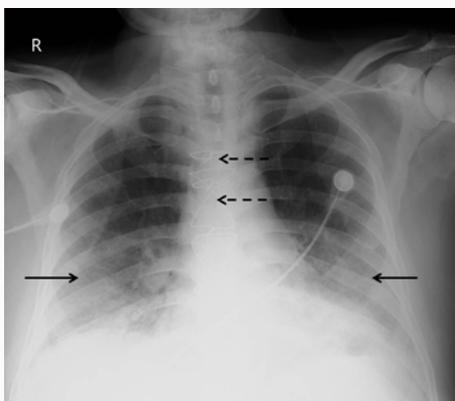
AP chest radiograph of 76-year-old male, known case of coronary artery disease (post CABG), with diffuse air space opacification bilateral mid and lower zones (black arrows). Note the presence of sternal sutures *in situ* (dashed arrow).
